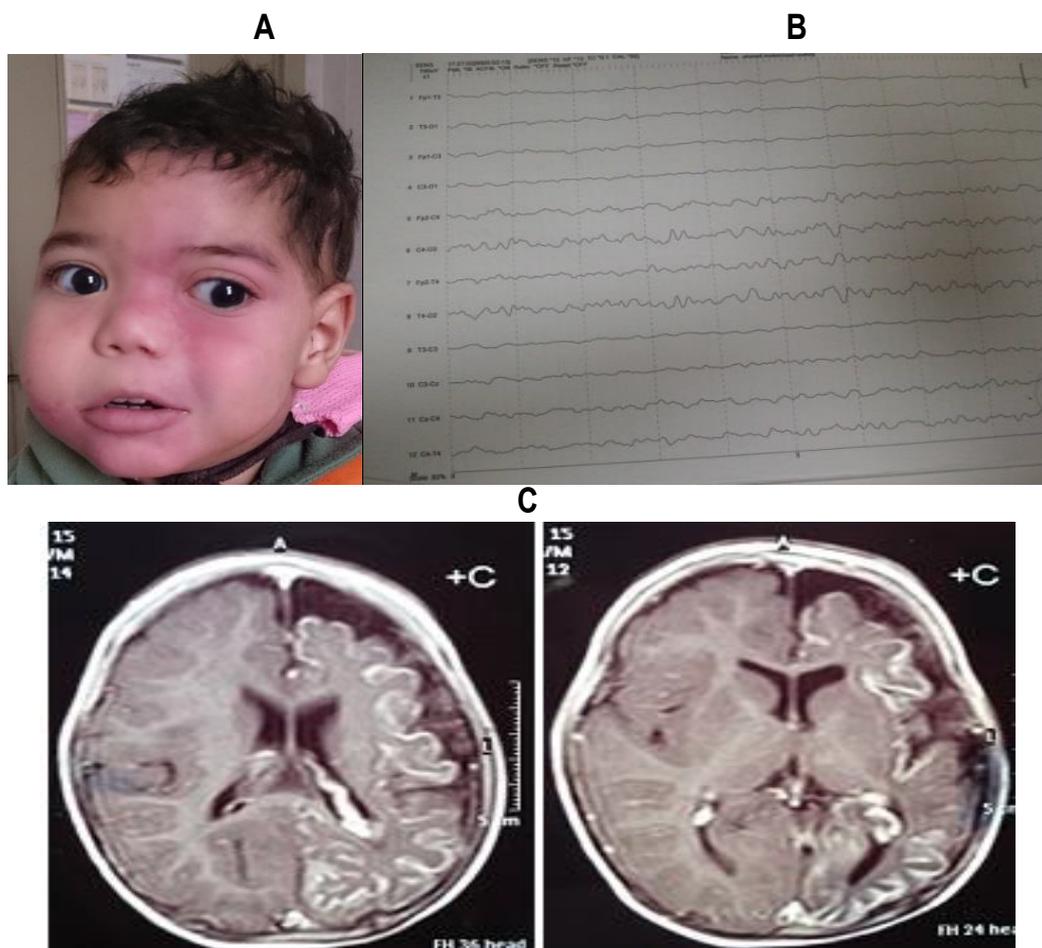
(A) Patient no 1: 2 years old child diagnosed as Sturge Weber syndrome. There is associated right hemifacial hypertrophy. Congenital hemangioma affecting skin over right cheek, mandible and extends to right shoulder; (B) The child had delayed motor and mental milestones and bilateral congenital glaucoma.; (C) Brain CT showed reduce volume of left cerebral hemisphere with prominent leptomeningeal enhancement and enlarged ipsilateral choroid plexus. EEG showed left side hypoactivity.
